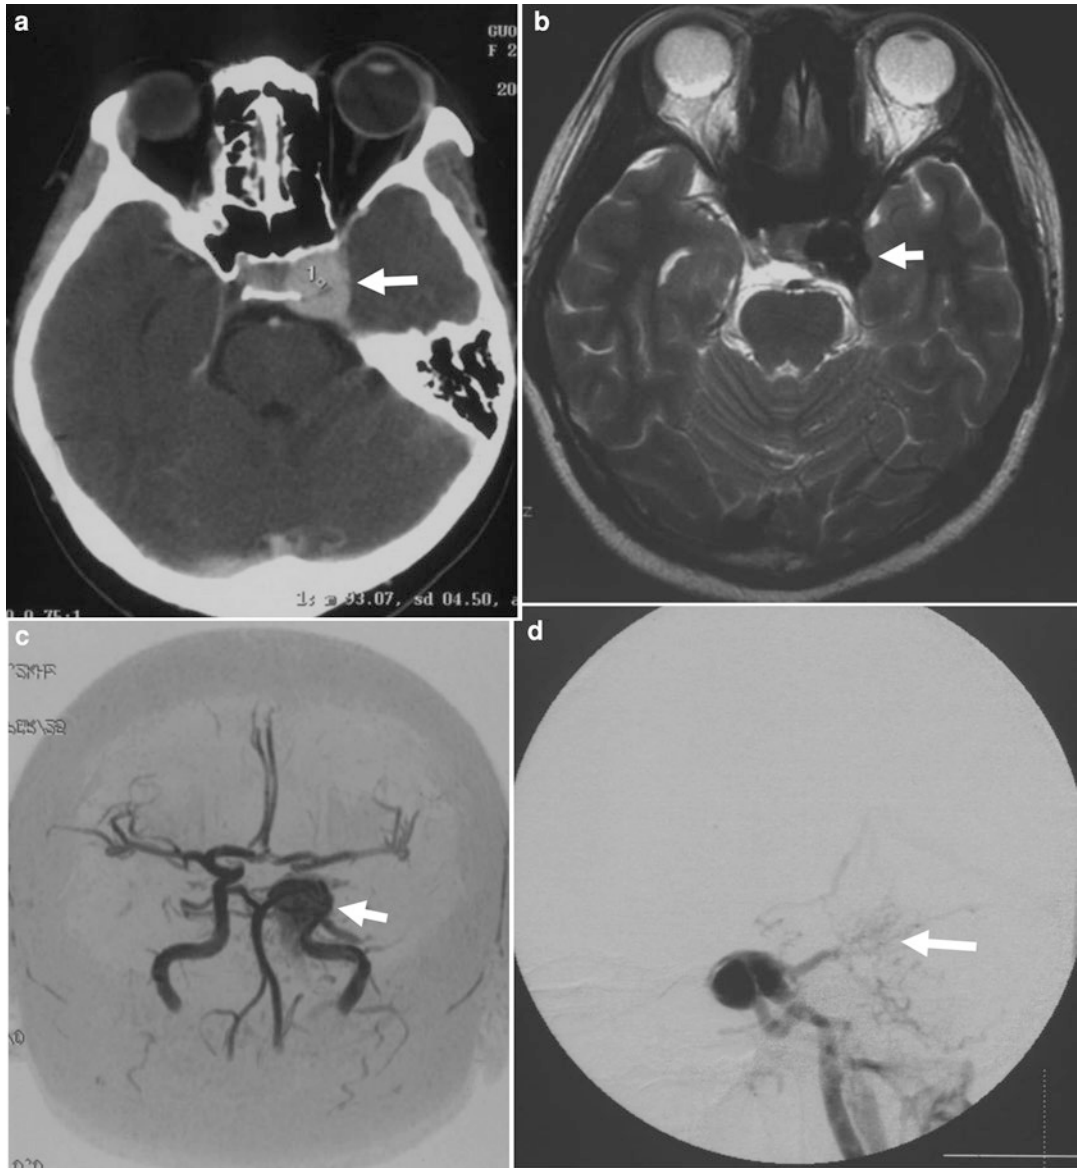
A 24-year-old female patient presented with the left oculomotor nerve palsy and intracranial bruits. (a) Cranial CT scanning showing a hyperdensity lesion at the left parasellar location (arrow). (b) MR imaging showing a flow void signal at the left parasellar location (arrow).
